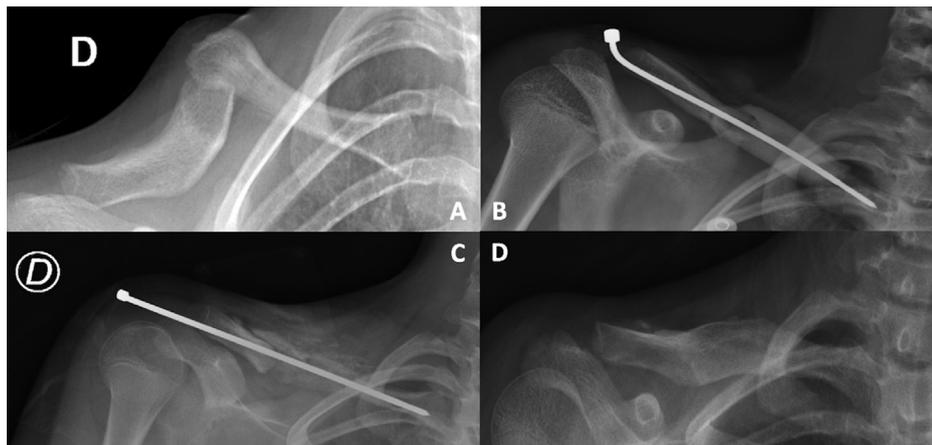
Patient #3, clavicular reconstruction for congenital pseudarthrosis of the right clavicle. A. Pre-operative radiograph. B. Radiograph taken immediately after the first stage of the induced membrane procedure. C. Radiograph taken immediately after the second stage of the induced membrane procedure. D. Radiograph taken at last follow-up after 1.2 years.
